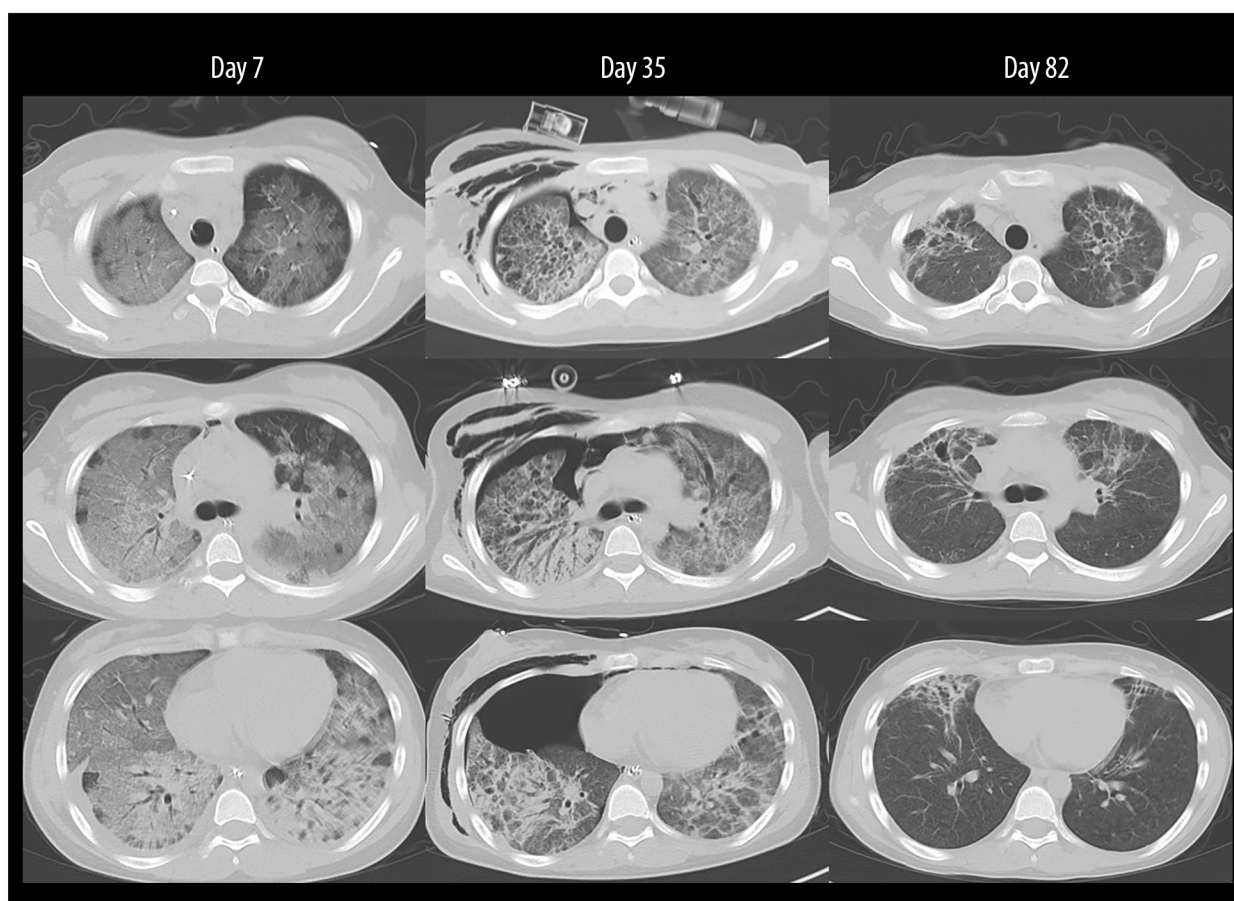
Serial chest computed tomography during the clinical course. Chest computed tomography scans performed on days 7, 35, and 82 after admission show the temporal evolution of lung injury. On day 7, diffuse bilateral ground-glass opacities and consolidation compatible with acute respiratory distress syndrome were observed. On day 35, persistent bilateral infiltrates with fibroproliferative changes were evident, and a right-sided pneumothorax requiring chest tube placement had developed. By day 82, the lung opacities had markedly improved, with substantial resolution of the previously observed abnormalities.
